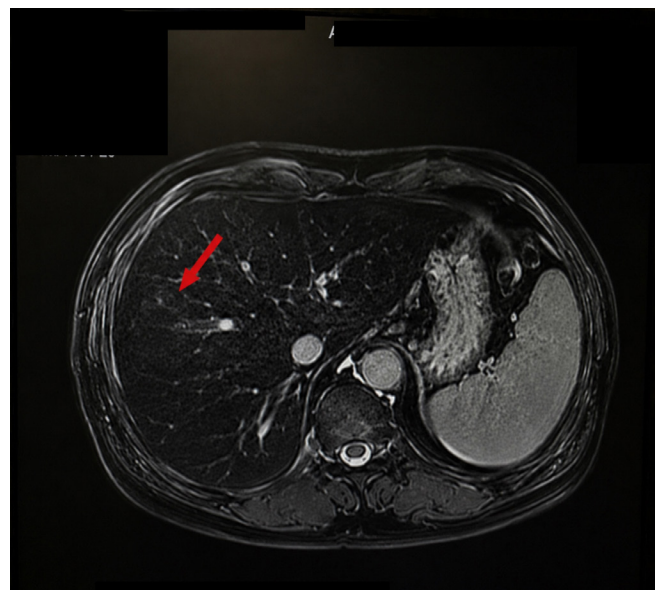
Axial T2-weighted HASTE magnetic resonance image showing diffuse low signal intensity of the liver parenchyma (red arrow), suggestive of hepatic iron deposition
